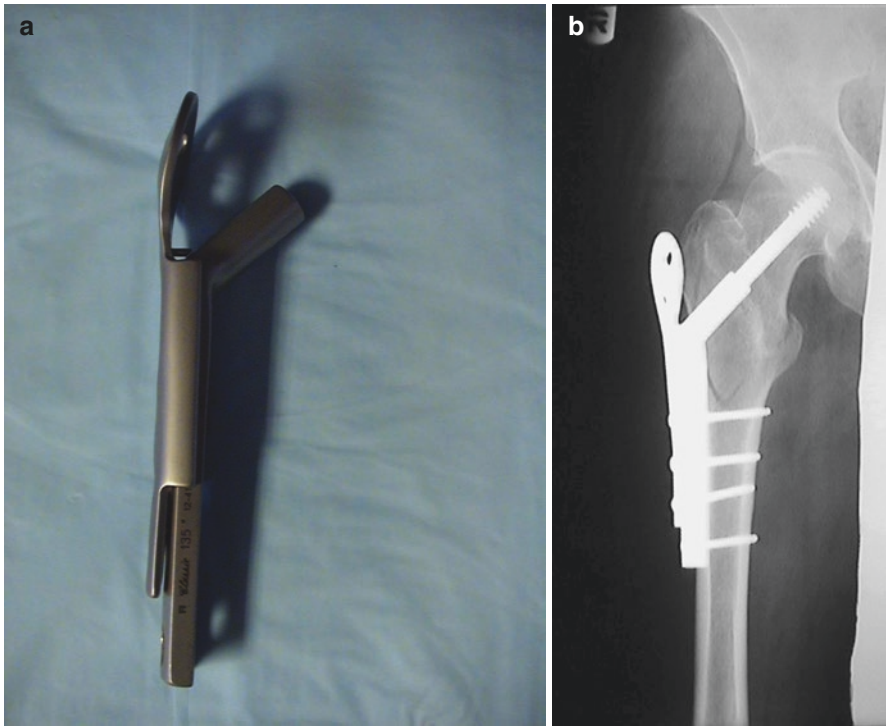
(a) Side profile of a lateral trochanteric stabilizing plate (TSP) attached to a standard barrel hip screw side plate. (b) AP radiograph of a right hip demonstrating treatment of a pertrochanteric hip fracture with lateral wall incompetence with a TSP
